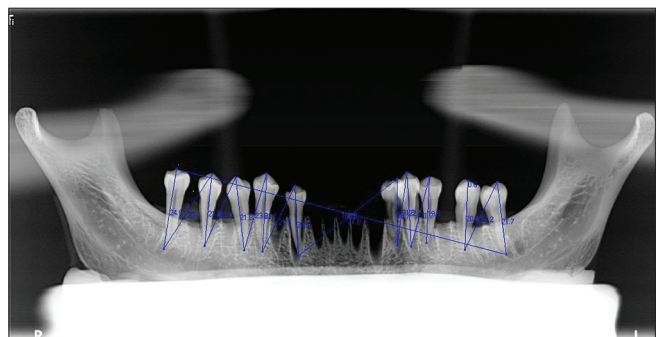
Measurement by orthopantomogram
